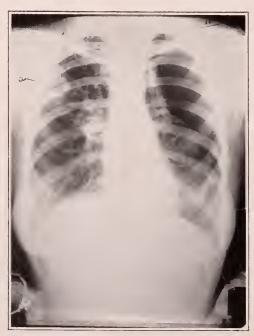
Case VII, roentgenogram on April 22, 1931, showing distinct cavitation in the right lung (a), and satisfactory collapse still maintained on the left side.
